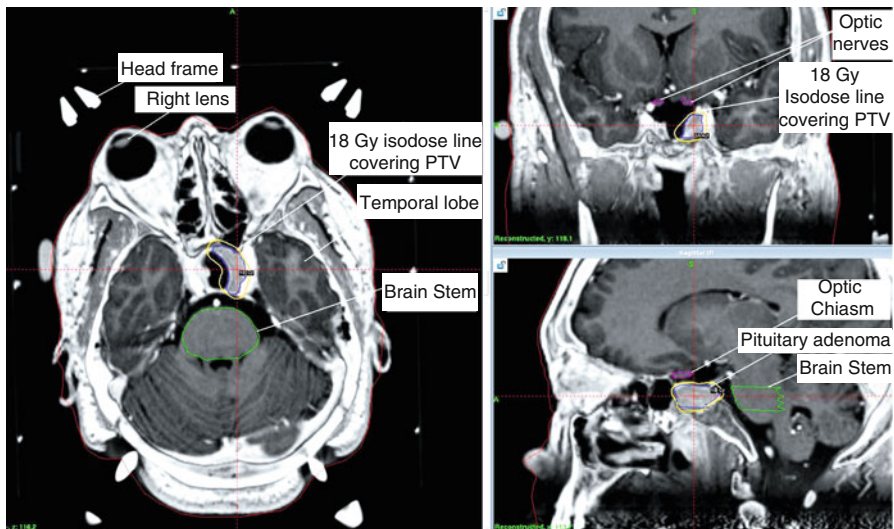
Pituitary adenoma on axial, coronal, and sagittal CT/MRI fusion (gadolinium-enhanced T1 sequence fused with contrast-enhanced planning CT) treated with SRS
